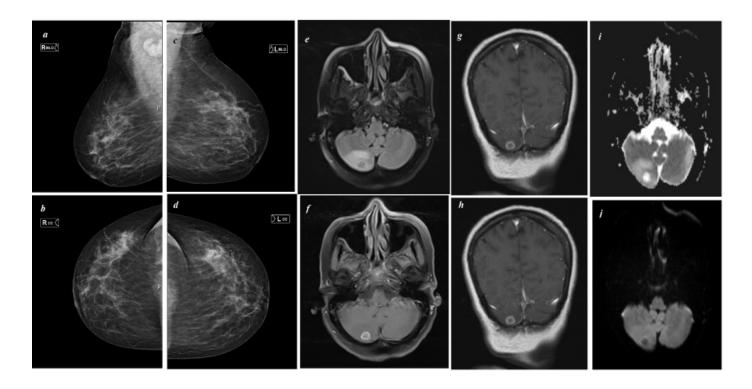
BIRADS-3 findings were observed in the mammography imaging (a,b,c,d). In cranial MR imaging; right cerebellar hemisphere posteromedial section has T2-Flair A (e) peripheral hyperintense edema area measuring approximately 10x12 mm in its widest dimension, showing intense contrast enhancement in T1 hypointense postcontrast T1 series (f,g,h) and causing mild limitation in diffusion examination (i,j) mass lesion observed.
